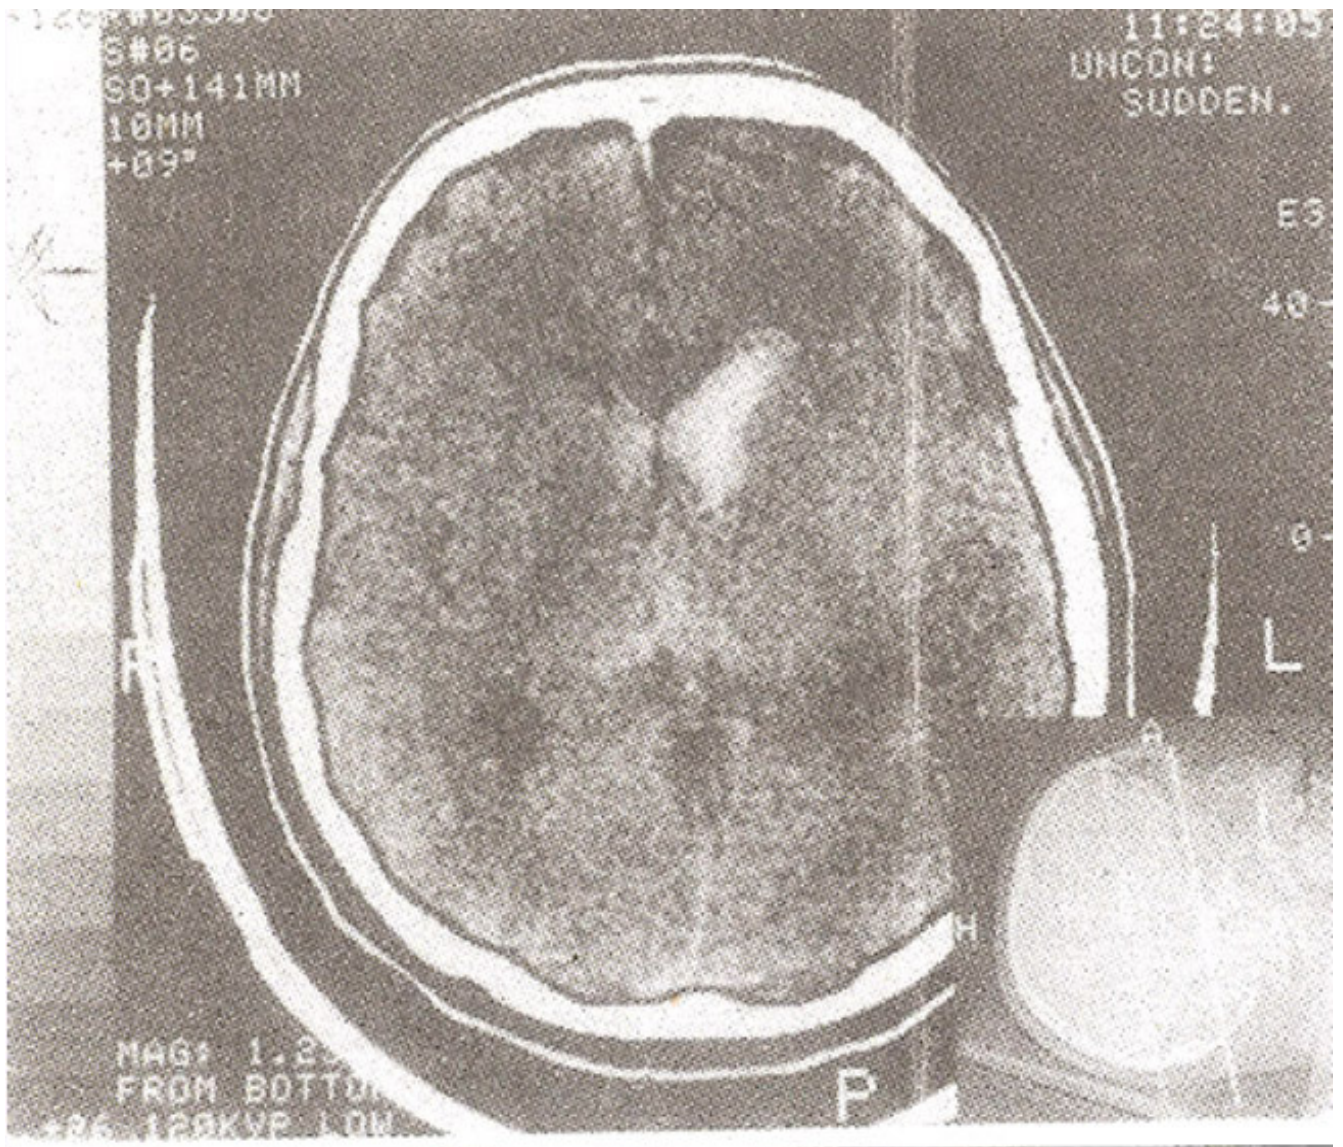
CT scan showing intra ventricular haemorrhage.
